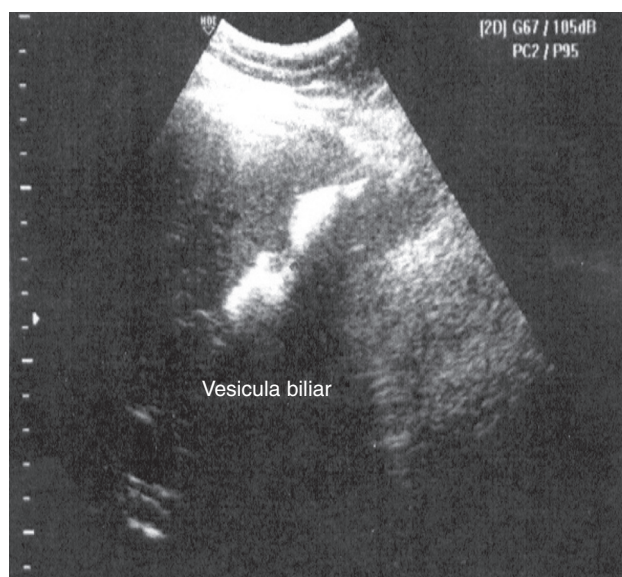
Ultrasonografía que concluye el diagnóstico de colecolitiasis.
